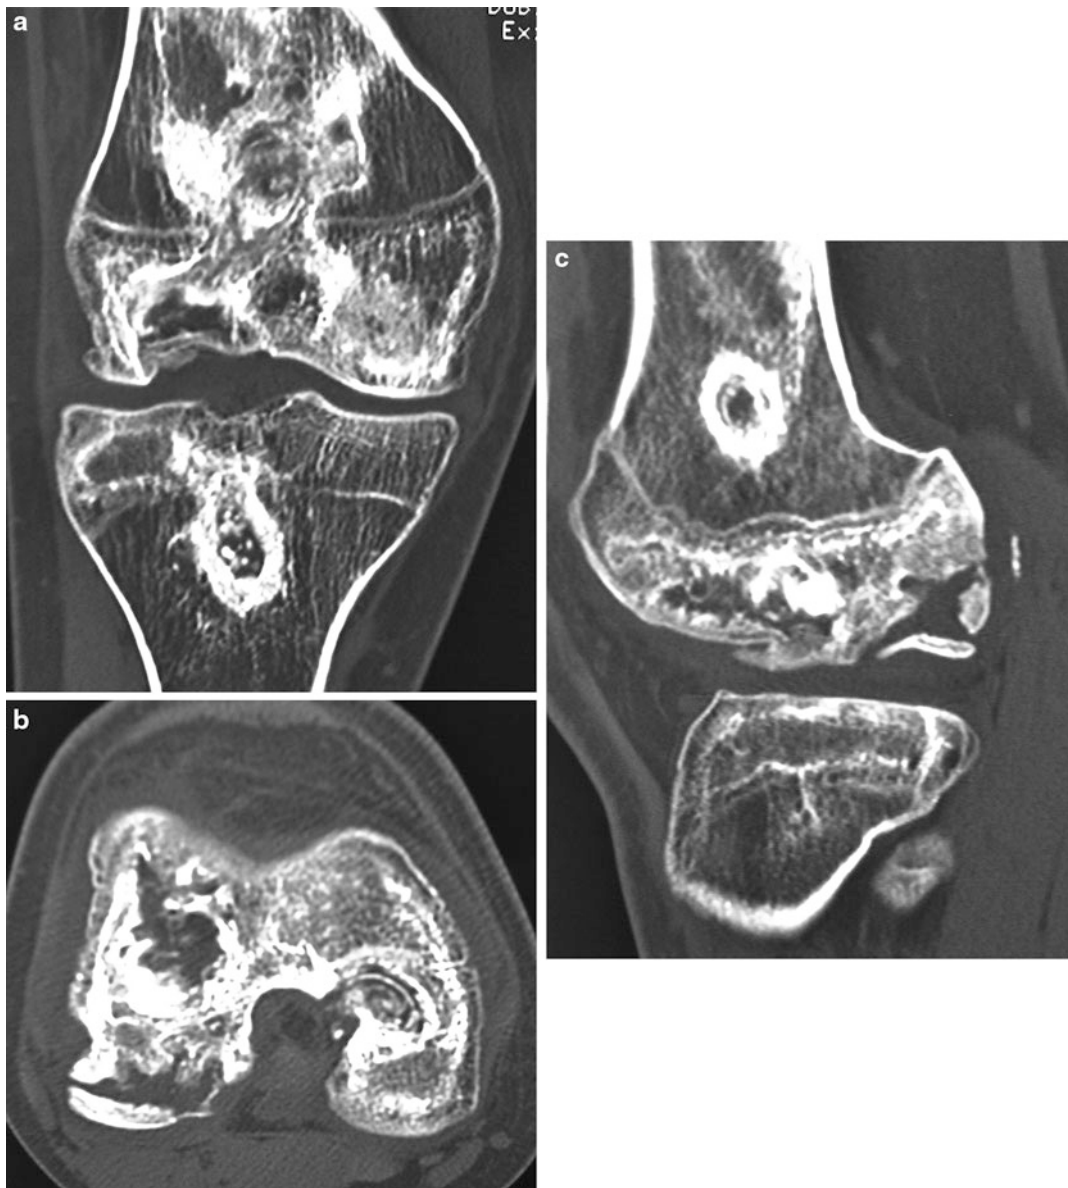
(a–c) CT scan images of right knee showing extensive areas of osteonecrosis, with advanced collapse of most of the lateral femoral condyle. (a) (coronal), (b) (axial), and (c) (sagittal)
